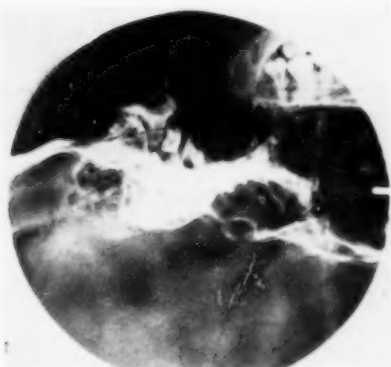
Case L. K., lateral roentgenogram of skull. Tip of odontoid process (outlined) above line drawn from hard palate to foramen magnum ("Chamberlain's line").
